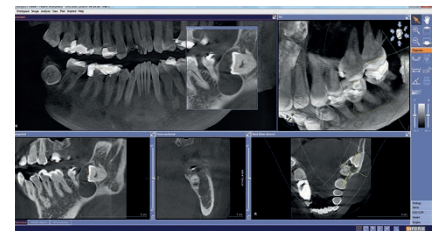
CBCT showing distinct radiolucency around impacted 38 with buccal extension around 37
